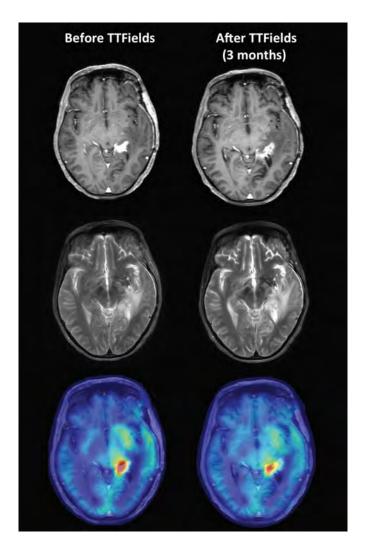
MRI (post-gadolinium T1-weighted [T1-Gad] and noncontrast T2 images) and alpha[C-11]-methyl-L-tryptophan (AMT)-PET/T1-Gad MR fusion images of a 45-year-old woman who showed MRI signs of tumor progression 2 months after completion of chemoradiation after resection of a left temporal lobe glioblastoma. Maintenance temozolomide therapy was continued and tumor-treating fields (TTFields) therapy was started after an AMT-PET scan acquired under a research protocol approved by the institutional review board.^{1–3} Alpha[C-11]-methyl-L-tryptophan SUV in the contrast-enhancing mass was 5.0, consistent with active tumor.² After 3 months of TTFields treatment, follow-up AMT-PET scan showed decreased tumoral SUV (3.7). T1-Gad MRI showed stable contrast enhancement during the same period and in subsequent follow-up scans. Tumor-treating fields therapy for newly diagnosed and recurrent glioblastomas applies low intensity, intermediate frequency (100 kHz-1 MHz), alternating electric fields that have antiproliferative properties.^{4,5} The treatment is delivered by the Optune® device with a recommended usage of at least 18 hours per day (75% compliance).6 In a phase 3 clinical trial for recurrent glioblastomas, TTFields treatment showed equivalent efficacy when compared to active chemotherapy. A randomized clinical trial also demonstrated a 5-month overall survival benefit from maintenance TTFields therapy plus temozolomide compared to temozolomide alone in supratentorial newly diagnosed glioblastoma after completion of chemoradiation. 8 Imaging studies evaluating response to TTFields treatment have been limited and confined to MRI. 9,10 The overall MRI tumor response rate was approximately 15%, and radiographic response developed slowly with a median of 5 months. Overall survival was longer in responders than in nonresponders. The present case and 2 additional patients, shown on Figures 2 and 3, demonstrate that amino acid PET may be more sensitive than MRI to detect early therapeutic responses to TTFields therapy, as metabolic effects can develop within 3 months after treatment initiation.
